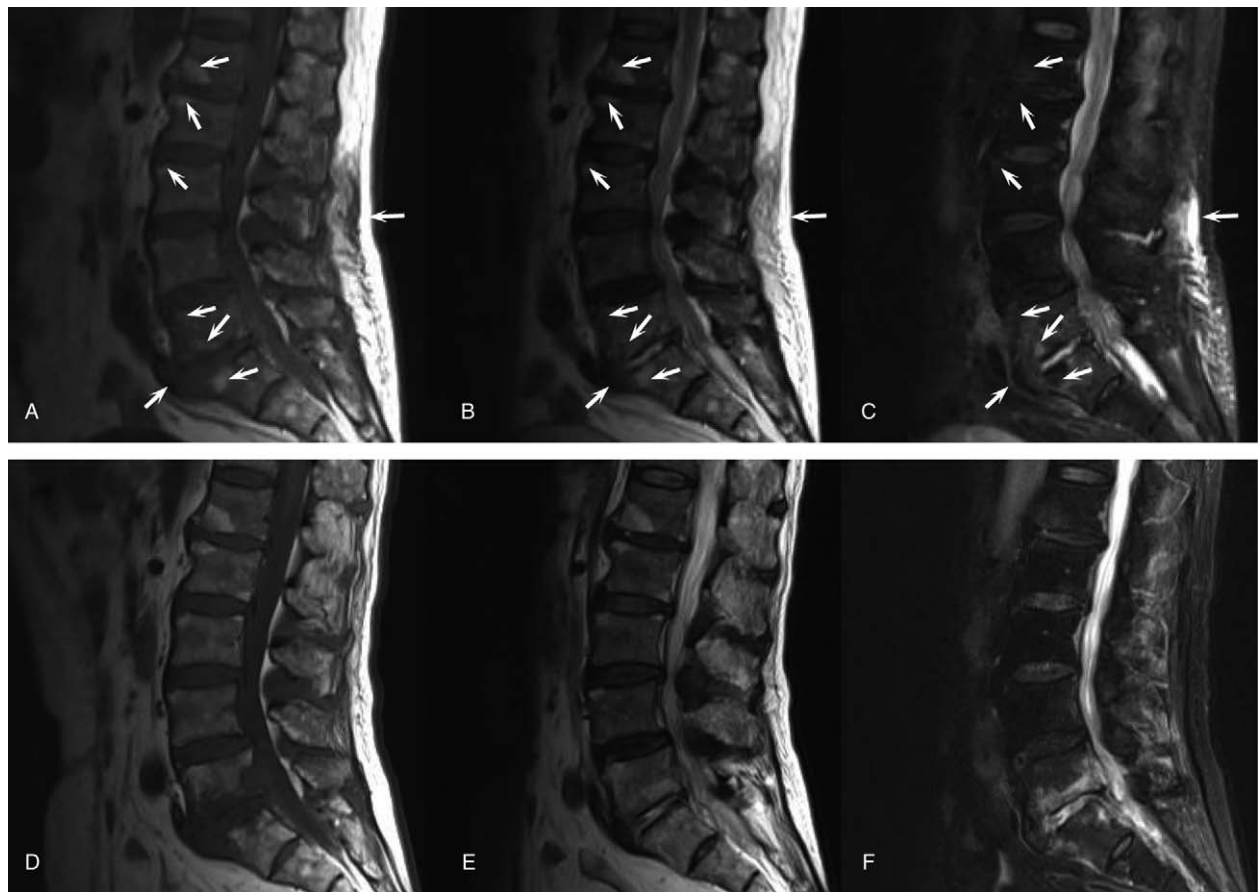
MRI of the lumbar region. (A, B and C) The initial contrast-enhanced MRI lumbar images. (A) T1 image. (B) T2 image. (C) Fat-suppressed image. Abnormal signal shadows in lumbar vertebrae 1-5 and sacrum 1, thickening of the soft tissue around lumbar vertebra 5 and sacrum 1, and an abnormal signal shadow from the soft tissue of the lower back were observed (marked with a white arrow). (D, E, and F) Follow-up MRI images 2 months later. (A) T1 image. (B) T2 image. (C) Fat-suppressed image.
